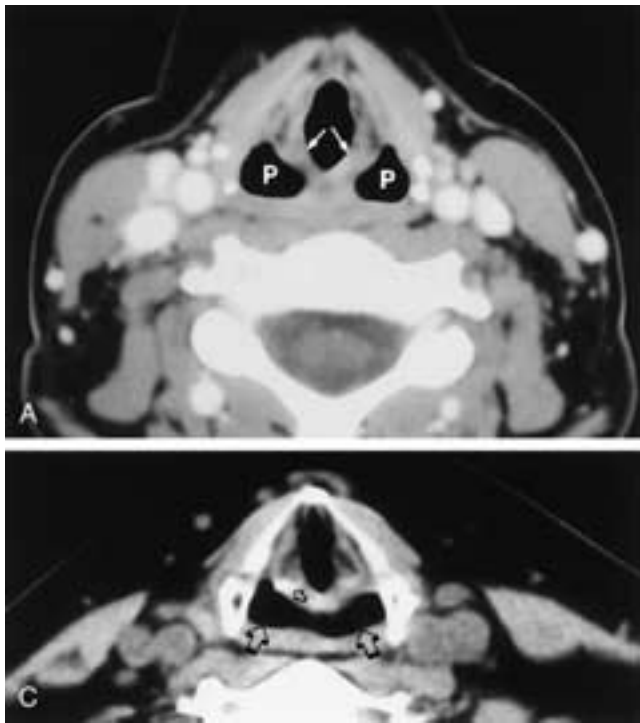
Normal hypopharynx—axial CT and MR studies. A, Axial CT scan through the pyriform sinuses (*P*) and aryepiglottic folds (*arrows*). B, T1-weighted MR image after gadolinium administration shows normal enhancement of the mucosa of the aryepiglottic folds (*white arrow*). The thin, smooth mucosa (*highlighted arrow*) of the pyriform sinuses (*p*) also enhances. C, Normal axial CT scan of another patient shows air distending the hypopharynx (*large open arrows*). Arytenoid cartilage (*small open arrow*).
